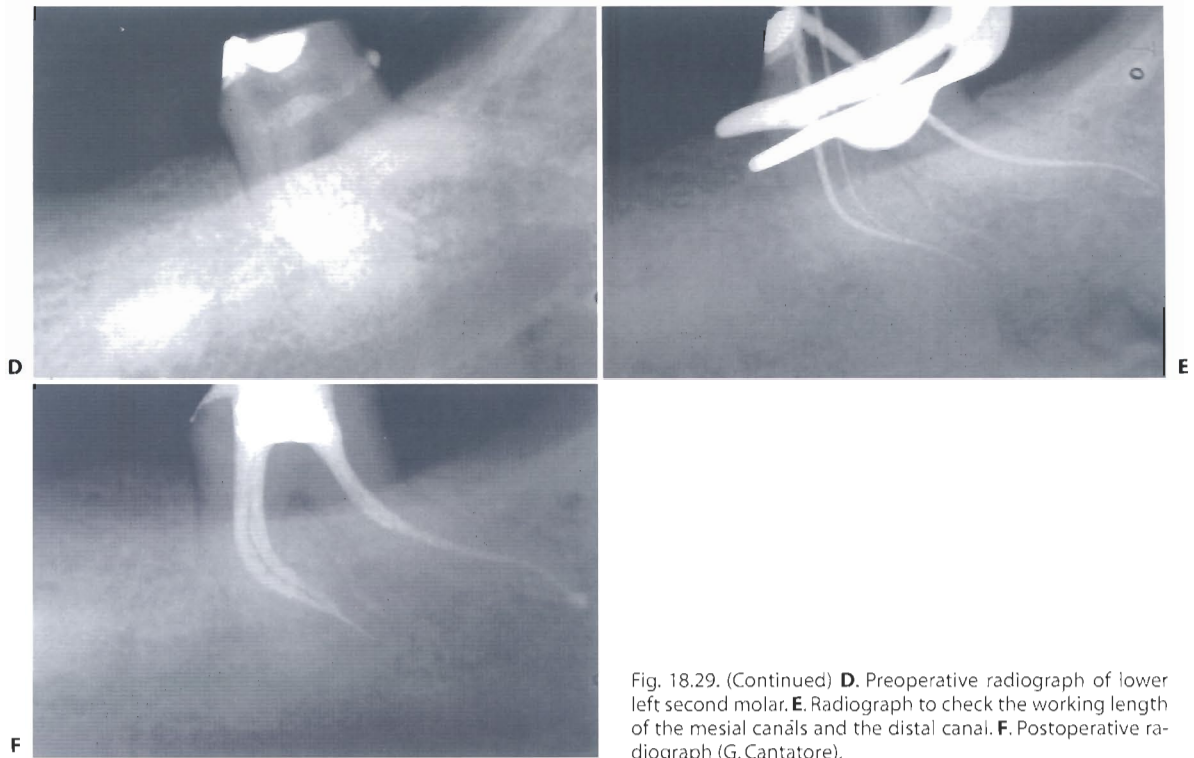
(Continued) D. Preoperative radiograph of lower left second molar. E. Radiograph to check the working length of the mesial canals and the distal canal. F. Postoperative radiograph (G. Cantatore).
